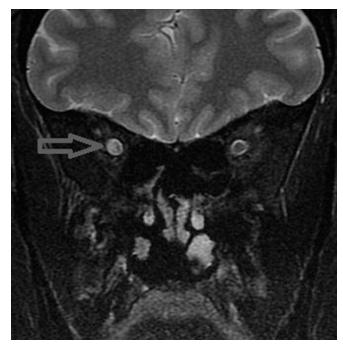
Coronal T2 MRI image demonstrating hyperintensity in the right optic nerve at the intracanalicular segment.
